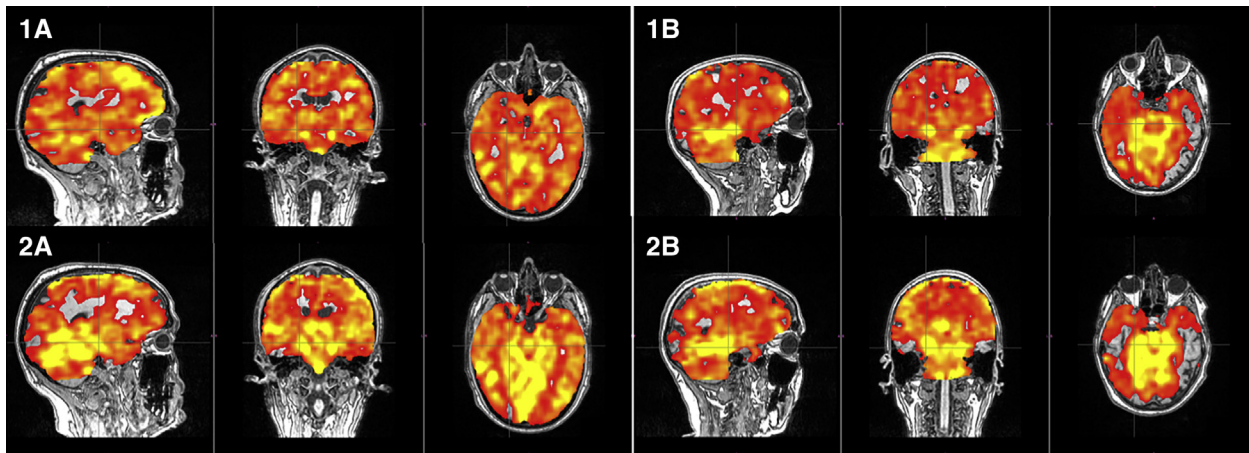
Pre- and post-ultrasound arterial spin labeling (ASL) sequences demonstrating a color map of relative blood flow perfusion with red (lower) to yellow (higher) perfusion values, which was registered and superimposed over a T1-weighted MRI of the brain. Four three-panel images demonstrate the results of 2 patients (A and B) (1) immediately before and (2) immediately after one-hour of ultrasound treatment.
